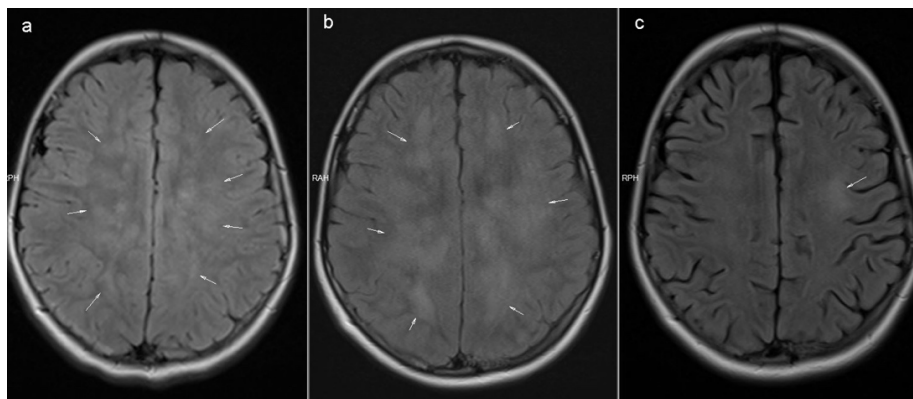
(a-c): Axial plane flair sequence of the patient on admission (a) demonstrates bilateral symmetric patchy and confluent white matter lesions in the centrum semiovale (arrows). One week later, the axial plane flair sequence of the follow-up MRI (b) shows that the white matter lesions coalesced over the 1-week period (arrows). One month later (c), the lesions substantially disappeared except for the left frontal cortical-subcortical lesion (arrow)
